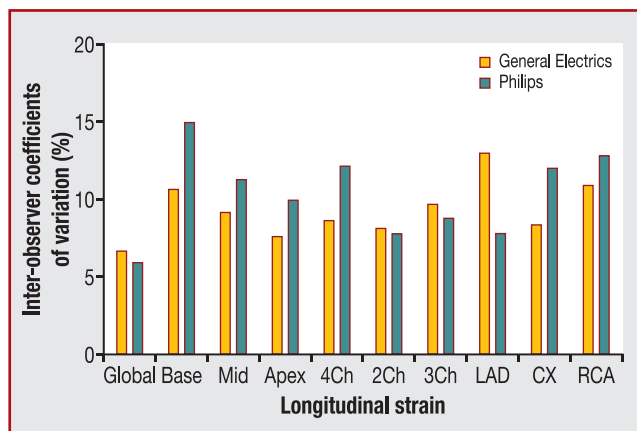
Interobserver coefficients of variation for longitudinal strains. 2Ch: apical two-chamber view; 3Ch: apical three-chamber view; 4Ch: apical four-chamber view; CX: circumflex artery; LAD: left anterior descending artery; RCA: right coronary artery.
